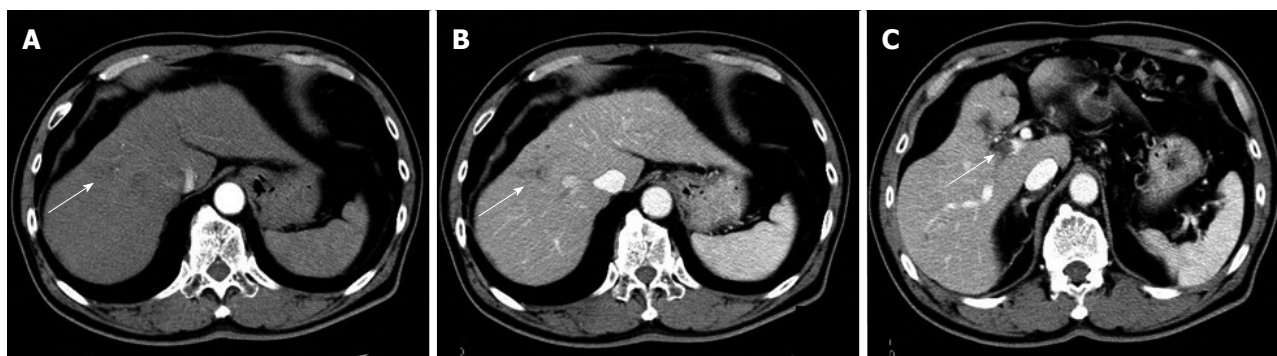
Two months after sorafenib induction. Computed tomography showed the significantly decrease in size (3 cm) and hypervascularization (A and B, arrow), and portal vein tumor thrombosis remained in the second-order branch of portal vein (C, arrow).
